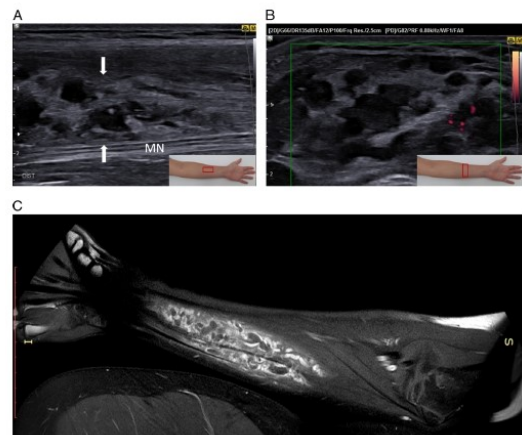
Ultrasound imaging of the anterior forearm in Case 1 (A, B). Insets show the transducer positions (red rectangles) during longitudinal (A) and axial (B) scanning. A well-margined cavernosal mass (white arrows) is seen in the flexor digitorum superficialis muscle belly adjacent to the median nerve (MN) (A). Power Doppler imaging shows mild signals (B). Magnetic resonance image of the hemangioma (C).
